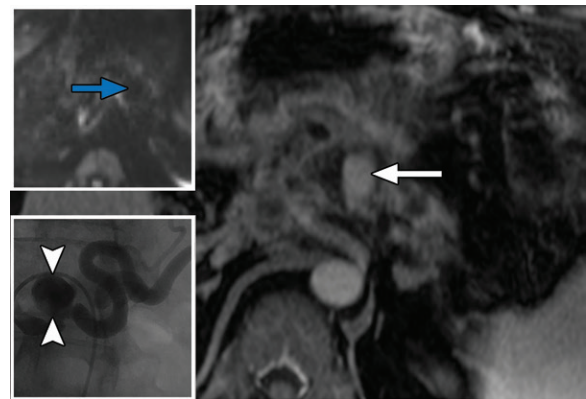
DWI as a vascular problem-solving tool in a 68-year-old man with pancreatic adenocarcinoma. Axial T1-weighted arterial phase MR image shows an enhancing "lesion" (white arrow) within a necrotic pancreatic mass. Diffusion-weighted image with a b value of 50 sec/mm² (top inset) shows no signal intensity (blue arrow), raising suspicion for a vascular abnormality rather than an enhancing solid mass. A splenic artery pseudoaneurysm (arrowheads) was queried and subsequently confirmed and treated at catheter angiography (bottom inset).
